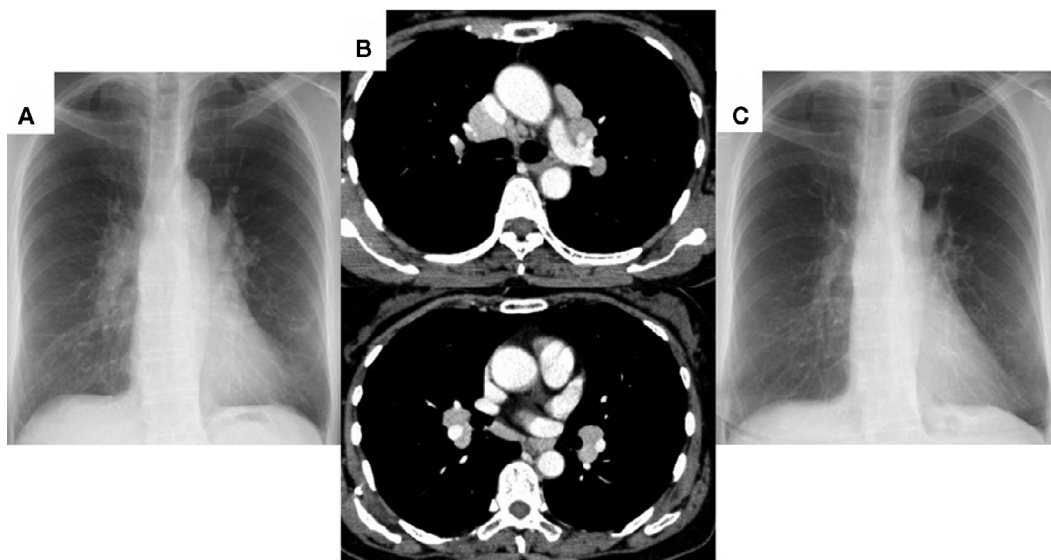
A chest radiograph taken at the age of 61 in a mass screening examination revealed bilateral hilar lymphadenopathy (BHL) (A), and computed tomography (CT) scan confirmed the presence of BHL (B). BHL remained unchanged, but eight years later at her age of 74, chest radiograph showed disappearance of BHL (C).
